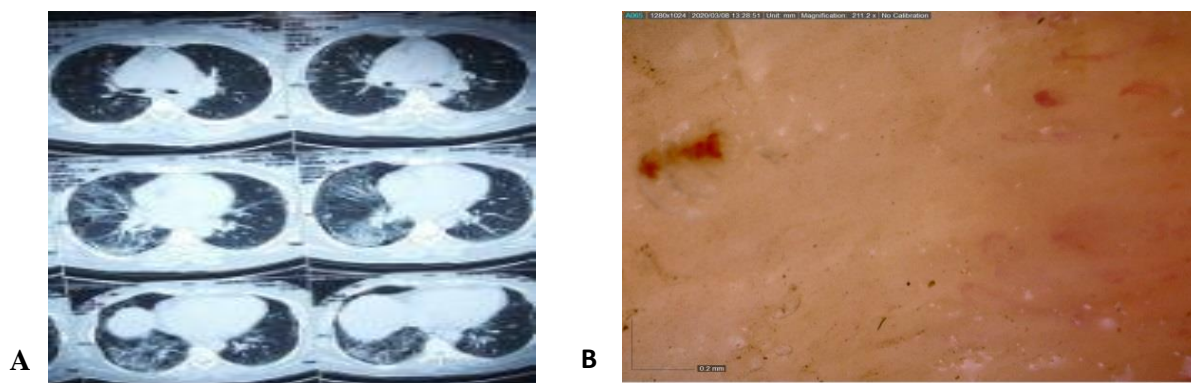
Female patients 40 years old presented with Raynaud's phenomena, distal skin thickening of both hands up to MCP associated with dysphagia and chronic cough. There were dyspnea grade 2 gradual onset progressive coarse bilateral extensive crackles. Pulmonary function test demonstrates severe Restrictive pattern. A: HRCT of the chest shows ground glass changes basal peripheral reticulations subpleural sparing. B: NFC shows giant capillaries, hge and avascular areas
